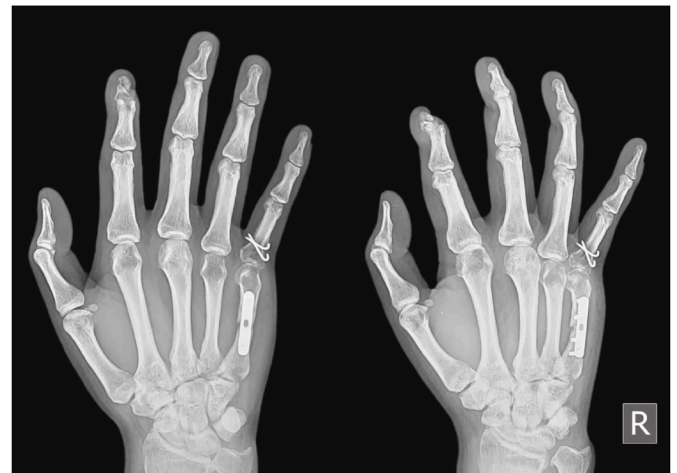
The anterior-posterior and oblique radiograph of right hand. See the union of distal phalanx has been reached within 3 months and the finger now in swan neck deformity.
